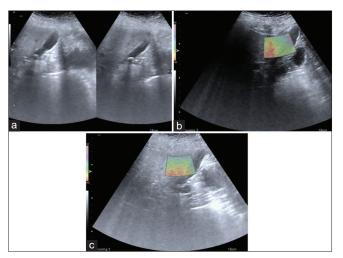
(a) Ultrasound image with gallbladder calculus (b and c) VTI images with adhesions E2 at two sites at body and neck. VTI: Virtual touch imaging
